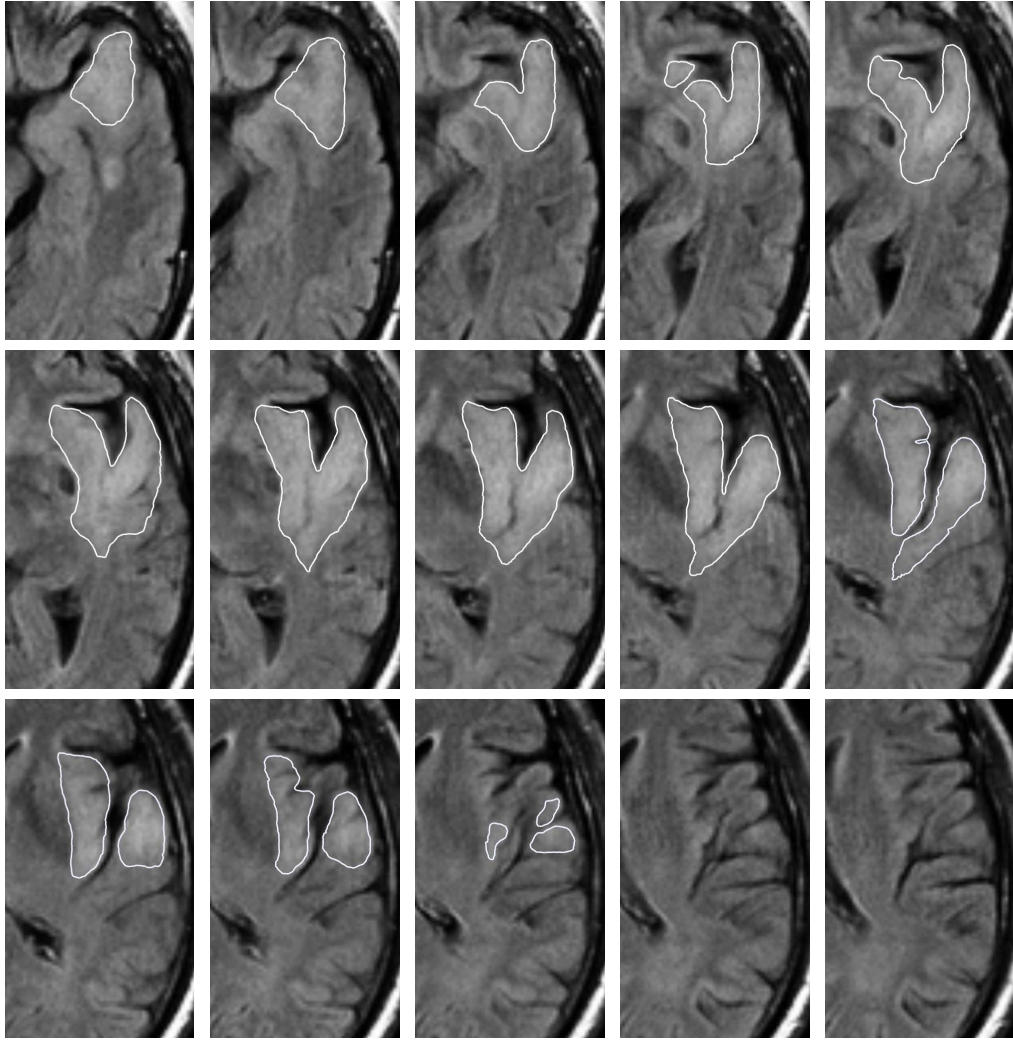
The MR image taken at the first time point for the second patient. White contour denotes the manual delineations.
